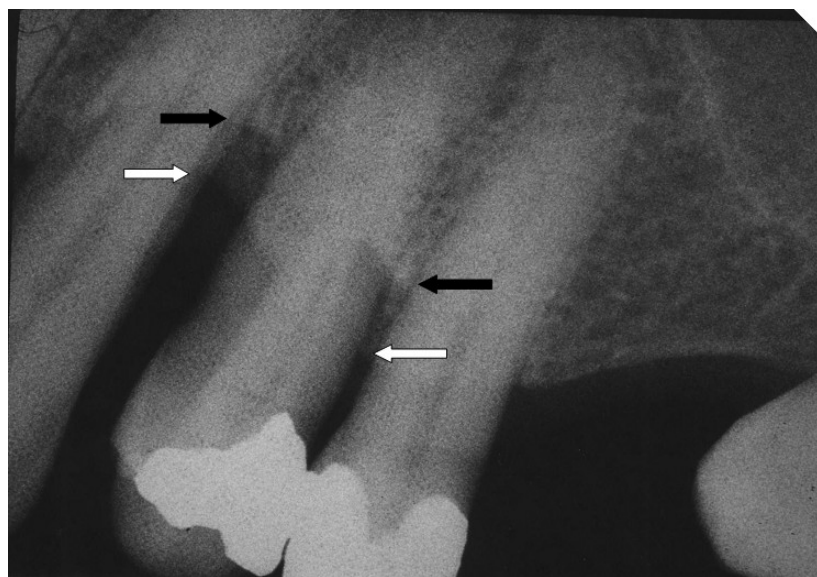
Radiograph of the same site 15 months postoperatively showing infill of the infrabony defects (see arrows) and an increase in radiodensity supracrestally, which has not matured to form the radiographic characteristics of bone. (White arrows = change; black = baseline.)
